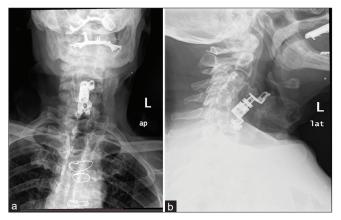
(a and b) Face and profile plain radiographs demonstrate cage anterior migration.
